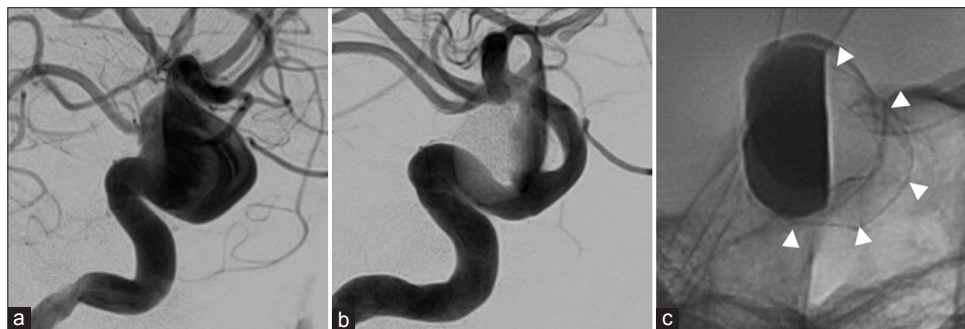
(a) The working angle of digital subtraction angiography (DSA) before flow diverter deployment is presented. (b) DSA immediately after deployment of the flow-diverting stent for the aneurysm showing an eclipse sign. (c) A flow-diverting stent was deployed and radiographs were taken. The flow diverter was confirmed to cover the neck of the aneurysm. Arrowheads indicate flow-diverting stents.
